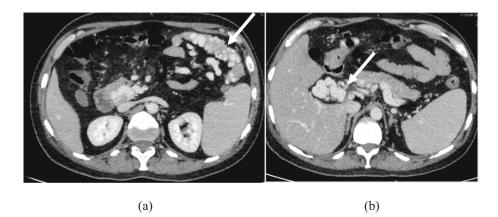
Shows the transverse sections of contrast enhanced CT of the abdomen, with (a) showing the dilated jejunal varices (white arrow) and (b) showing the obstructed extrahepatic portal vein with cavernoma formation (white arrow).
